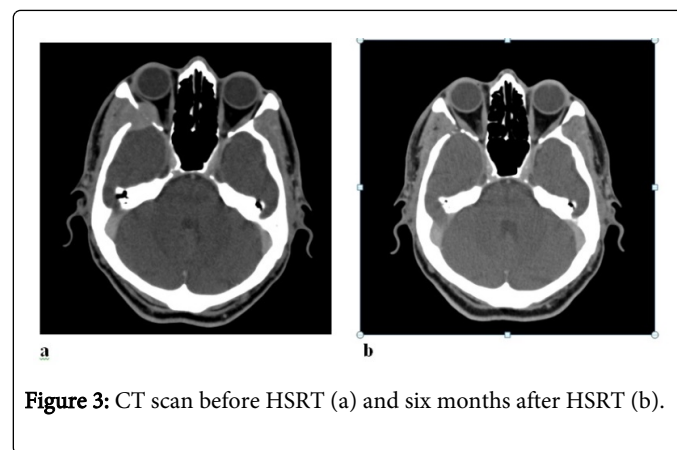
CT scan before HSRT (a) and six months after HSRT (b).
